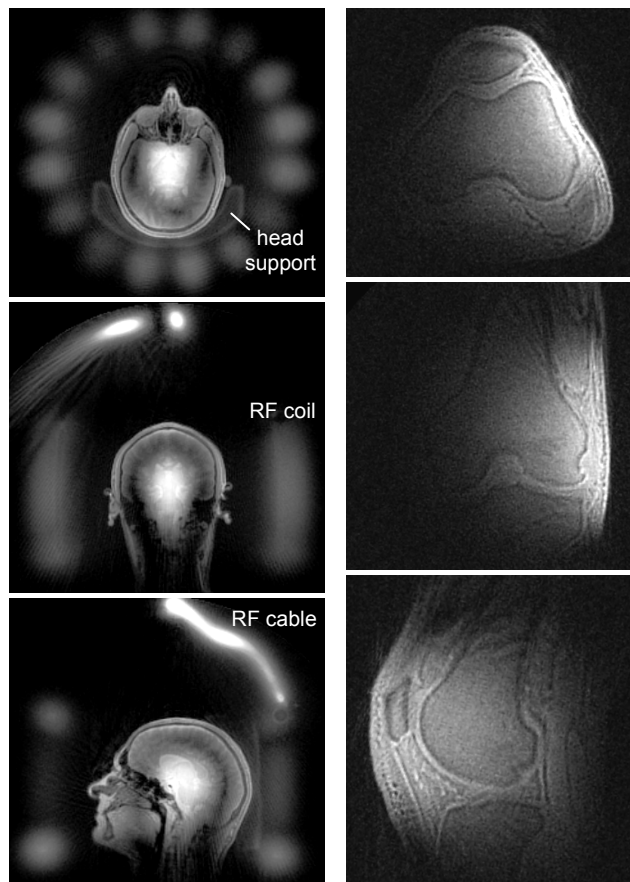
ZTE MRI of a human head
